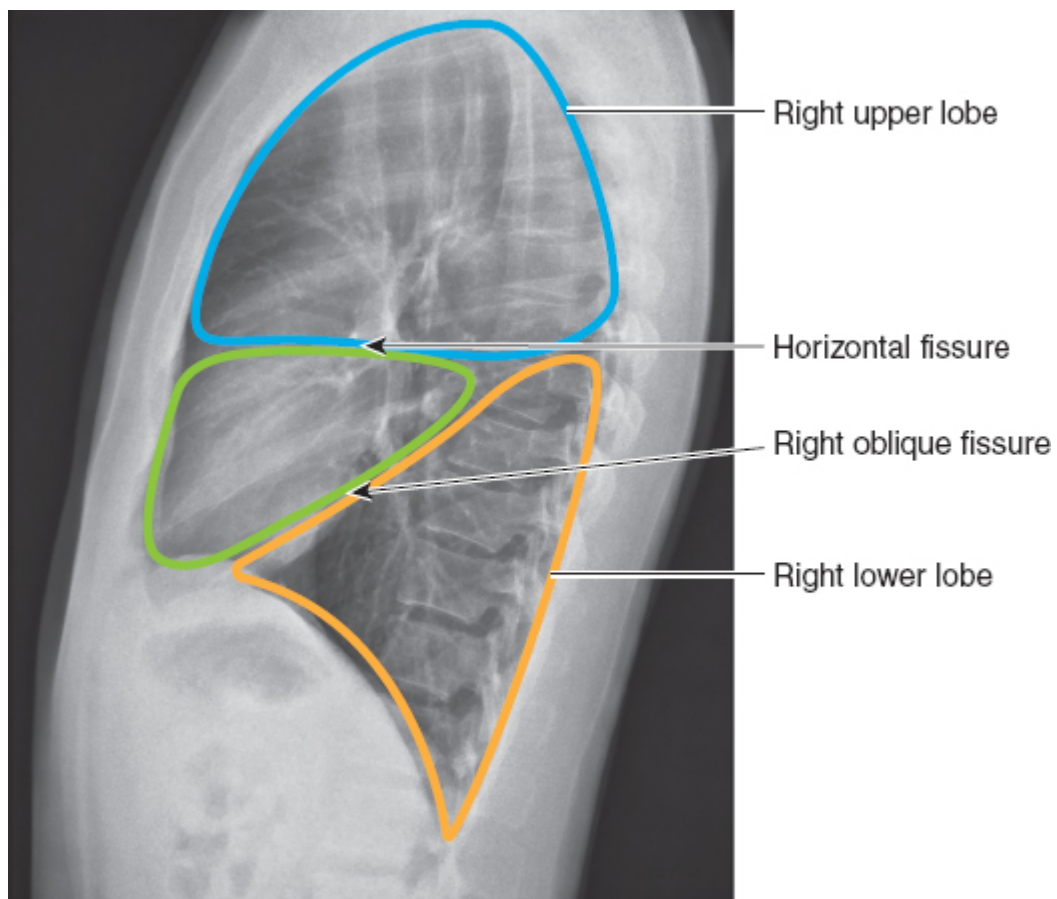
Lobes of the right lung in lateral view of a chest radiograph. (Modified from Brant WE, Helms CA. *Brant and Helms Solution: Fundamentals of Diagnostic Radiology*. 3rd ed. Lippincott Williams & Wilkins; 2007, [Fig. 21-2](#).)
